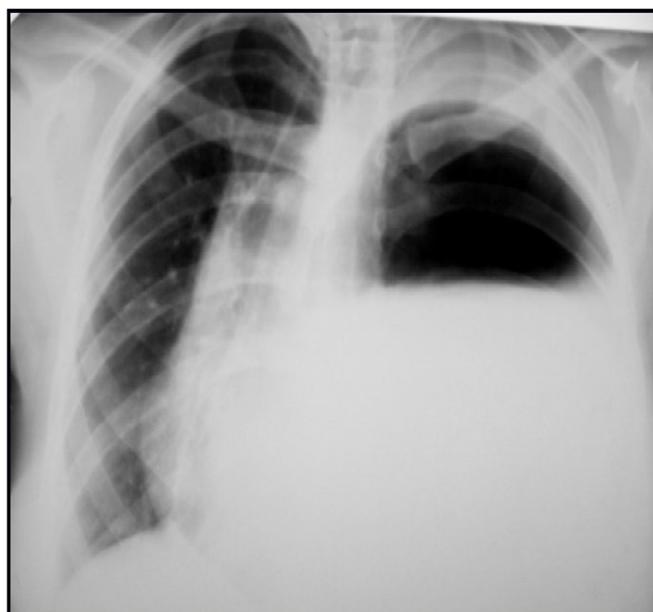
X-ray of the patient's chest.
